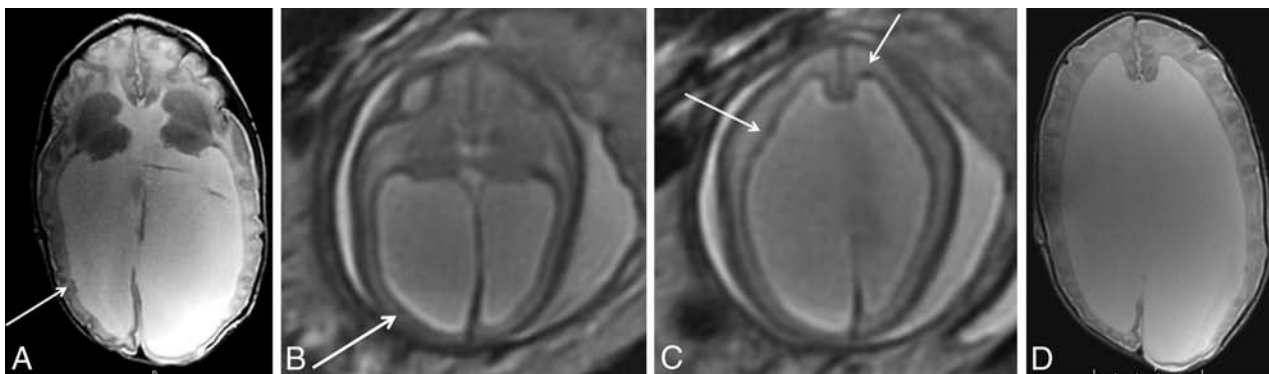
Example of a false-negative finding in a patient with SEH. Postnatal brain MR imaging at 15 days of age (A) demonstrates 2 small SEH along the right lateral ventricle (arrow) on axial T2 FSE imaging. In retrospect, there is some subtle asymmetric irregularity of the subependyma (arrow) on fetal MR imaging at 24 weeks' GA (B) on axial T2 single-shot fast spin-echo imaging. However, other areas of nodularity on fetal MR imaging in this patient (C, arrows) do not correspond to SEH postnatally (D).
